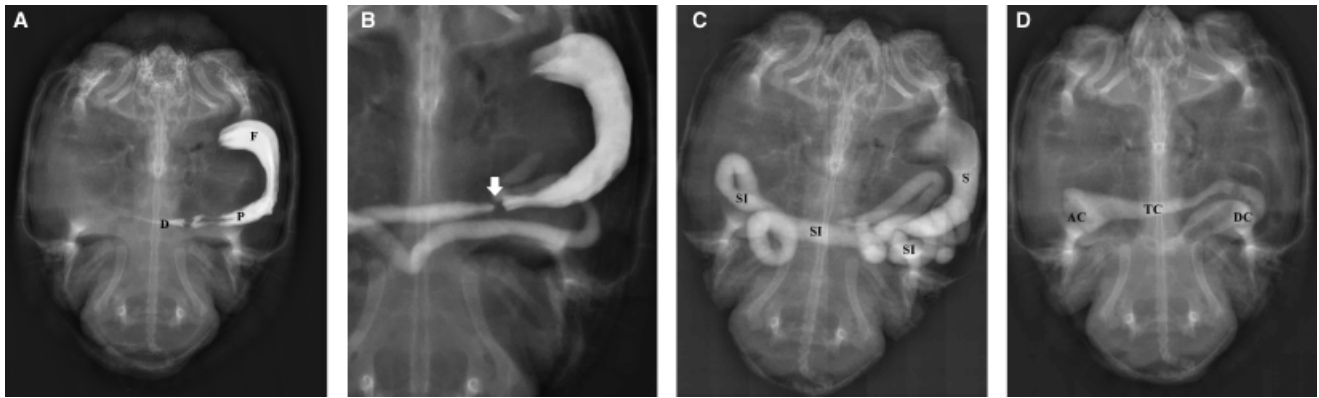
(A) Dorsoventral radiograph immediately after administration of Gastrografin[®]. Gastric folds are visible in the fundic (F) and pyloric (P) regions of the stomach. There is also a small amount of Gastrografin[®] in the proximal duodenum (D). (B) Dorsoventral radiograph one hour after administration of Gastrografin[®]. The pyloric sphincter (white arrow) creates a filling defect between the aboral portion of the stomach and the small intestine. (C) Dorsoventral radiograph 8 h after administration of Gastrografin[®]. Contrast medium has moved rapidly through the small intestine (SI) resulting in progressive distension and decreased contrast medium opacity (S, stomach). (D) Dorsoventral radiograph 32 h after administration of Gastrografin[®]. Contrast medium is still visible in the ascending (AC), transverse (TC), and descending (DC) colon, but it is less opaque than when it was in the stomach and small intestine.
